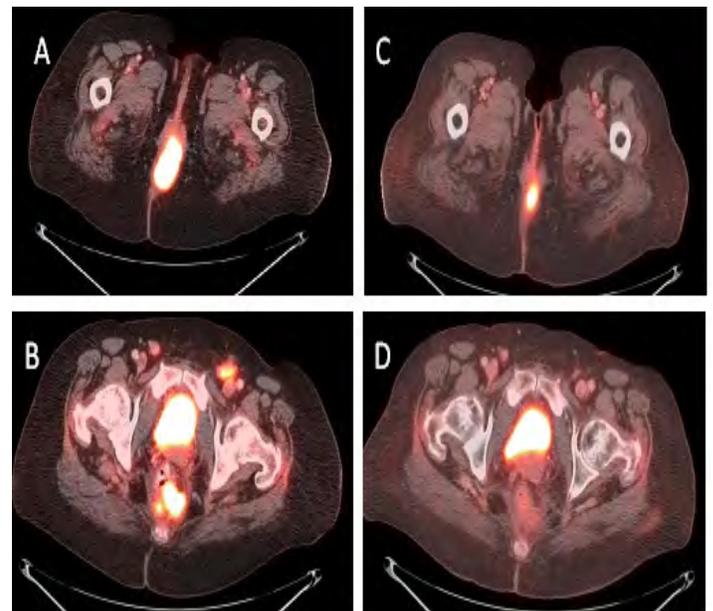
Axial images from 18-FDG PET/CT scans of the pelvis before (A) and after therapy (B) at the level of the rectum/anus. The anal tumor is hypermetabolic with pretherapy SUVmax of 20 and posttherapy SUVmax of 8.5. The cephalocaudal extent of the tumor was 13cm before therapy and it decreased to 7.7cm. Axial images from 18-FDG PET/CT scans of the pelvis before (C) and after therapy (D) at the level of inguinal lymph nodes. Hypermetabolic metastatic lymphadenopathy is seen on the left side with SUVmax of 6.3 in a lymph node with a short axis of 1.1cm. This resolved after therapy.
